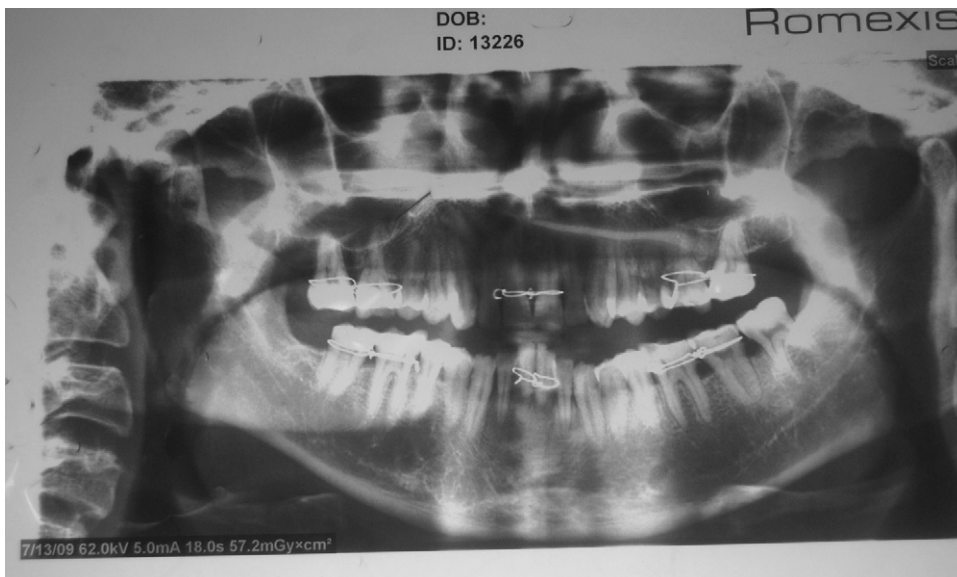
Postoperative orthopantomograph showing dislocated portion of condylar head.
